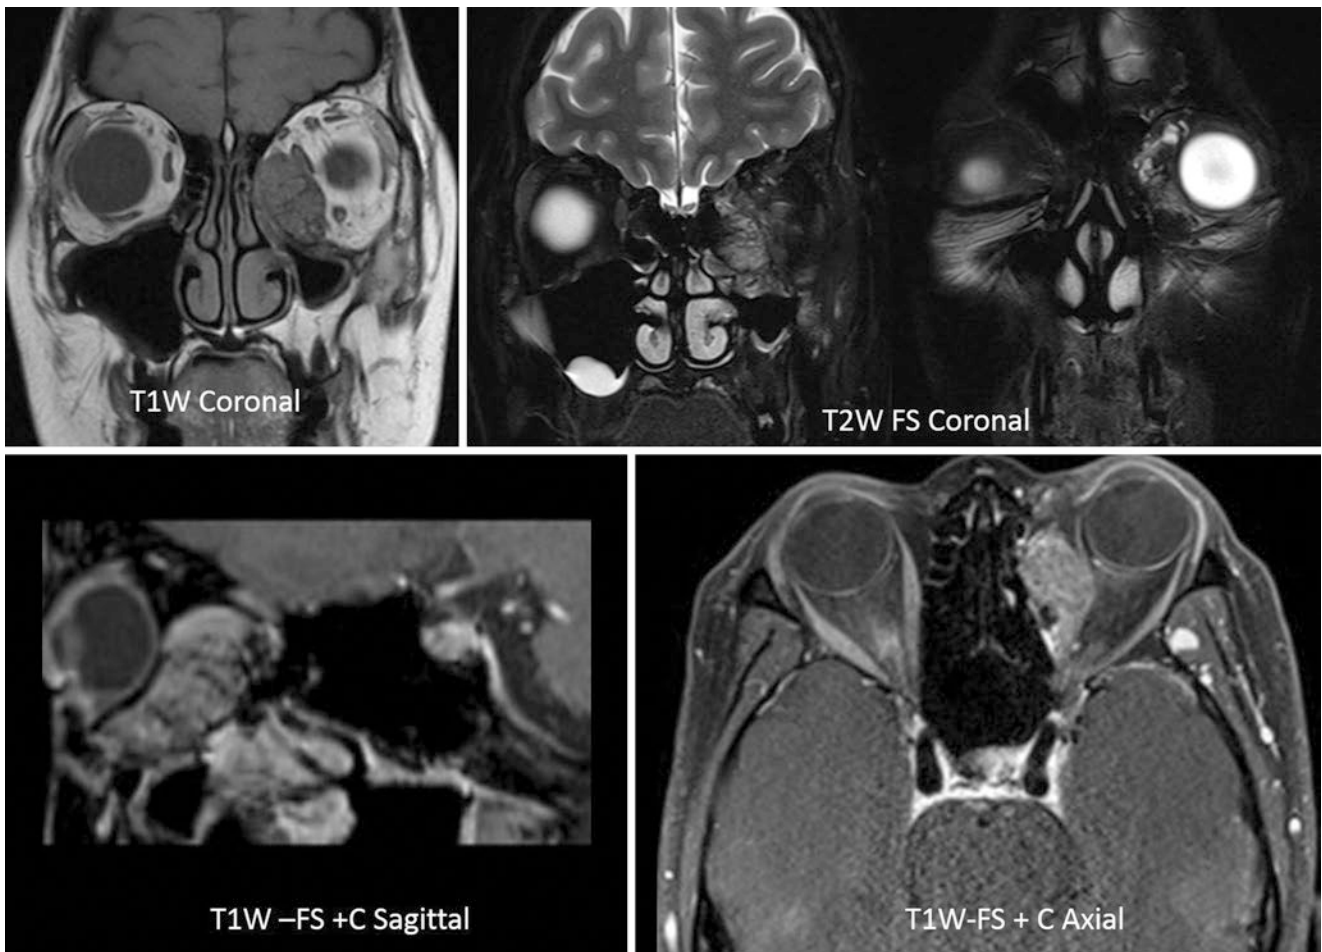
MRI images show a multilobulated mass in the inferomedial left orbit showing a microcystic pattern with fine, enhancing septations giving a spongiform appearance
